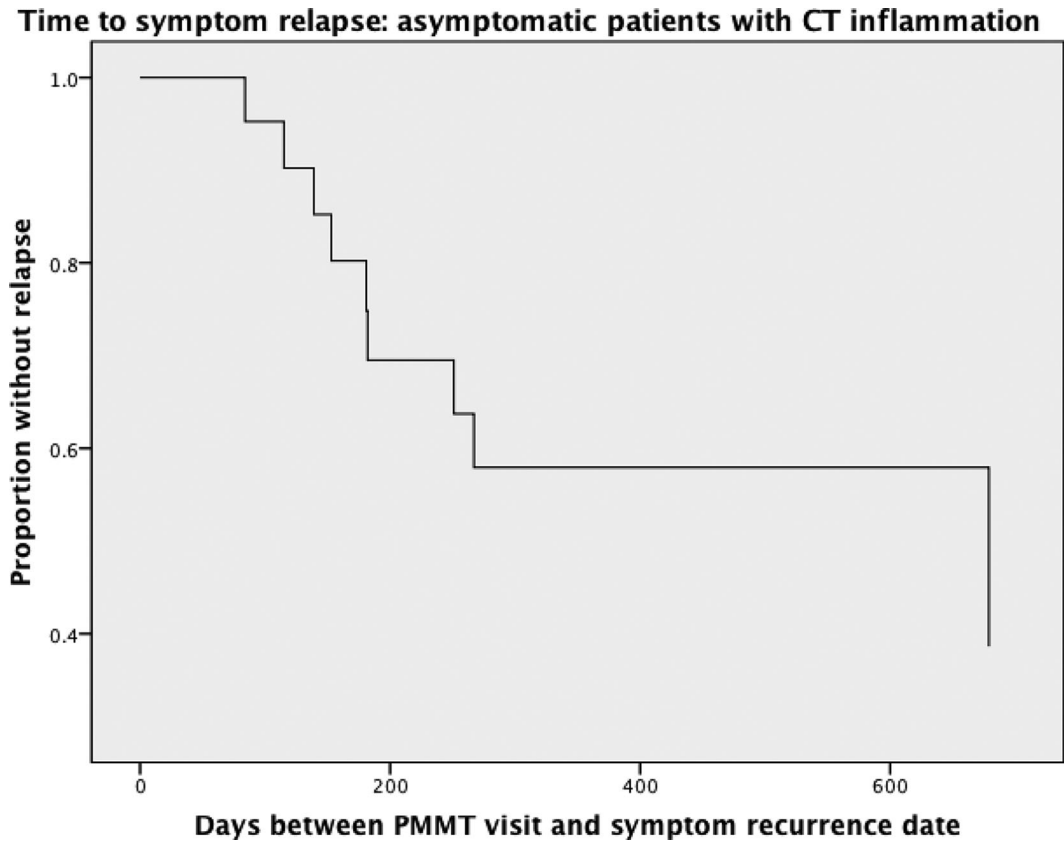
Time to symptom relapse among asymptomatic patients with CT inflammation. CT = computed tomography.
